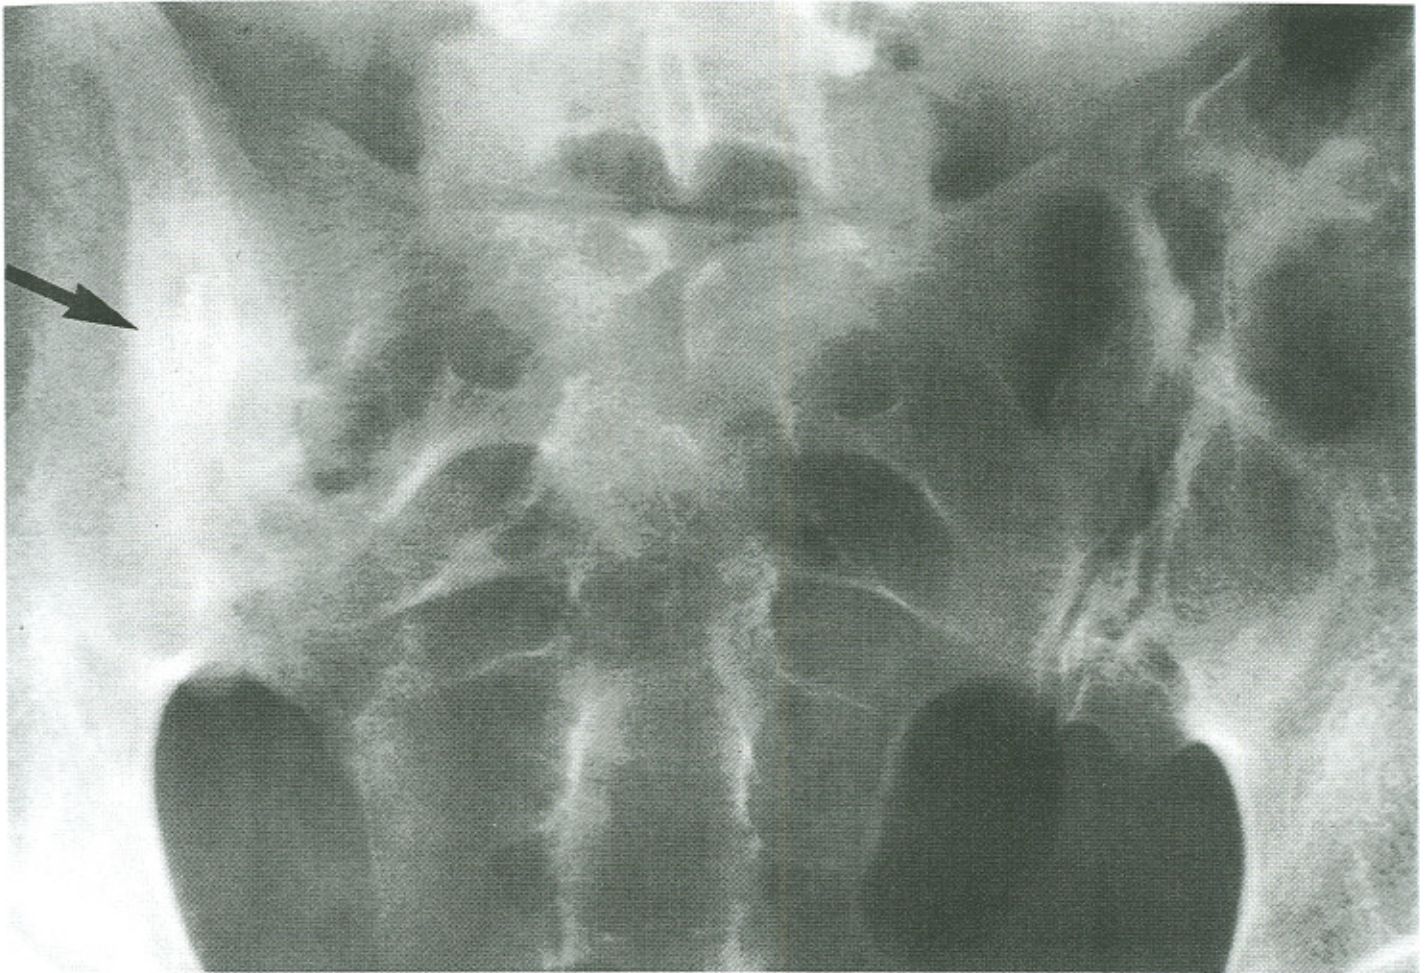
Ferguson's view radiograph of the SI joints of patient in case one, when seen at the chiropractic clinic, five months after the radiograph in Figure 1 was taken. Painful symptoms had been present for nine months at the time of this image. There is sclerosis affecting both sides of the infected joint and partial fusion (arrow). The right SI joint is normal.
